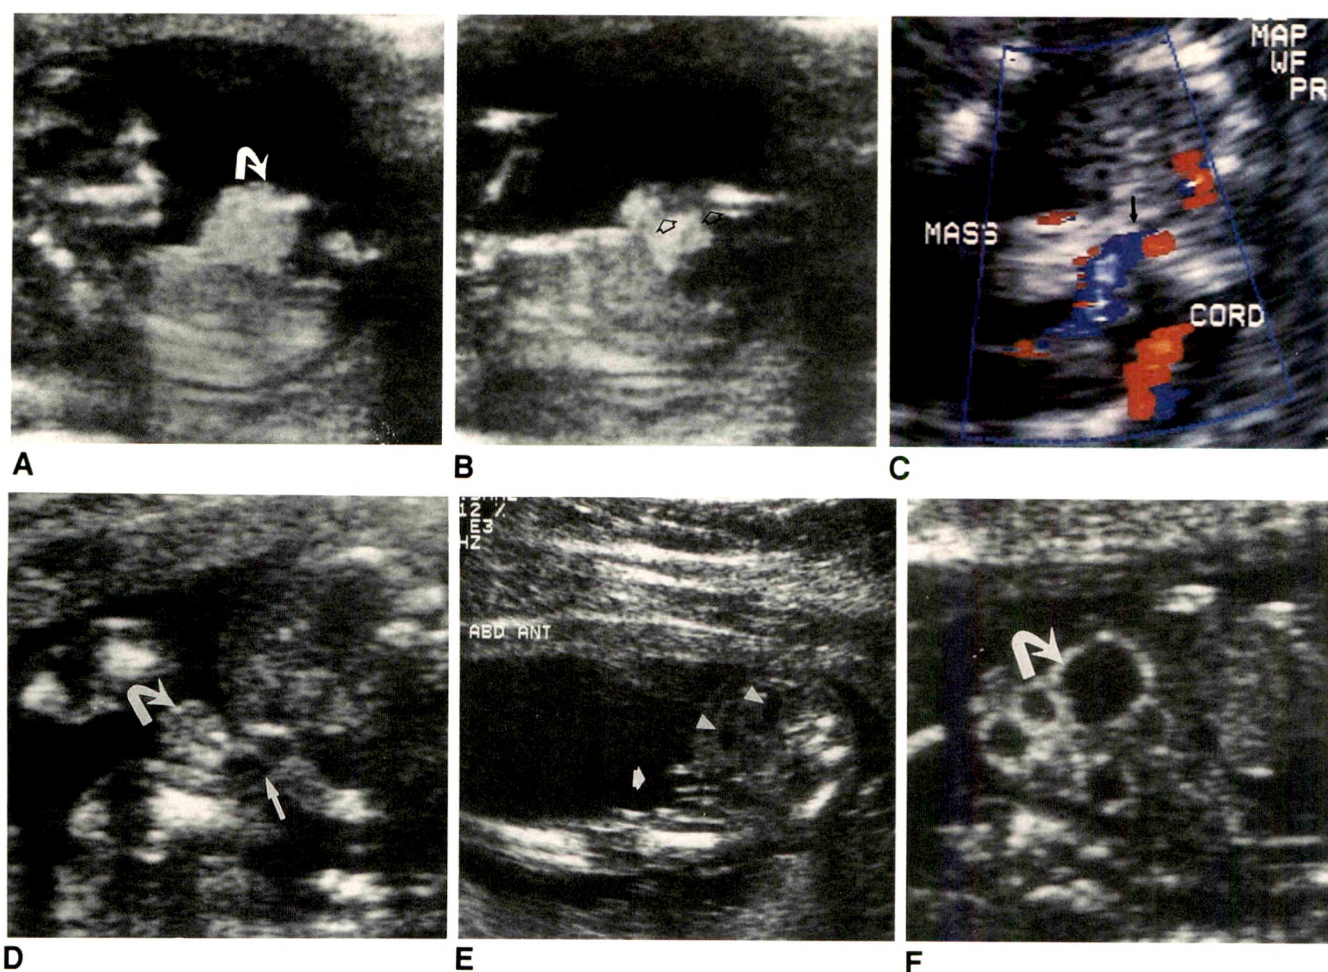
A, Sagittal sonogram of 12.7-week fetus with large omphalocele (arrow).
